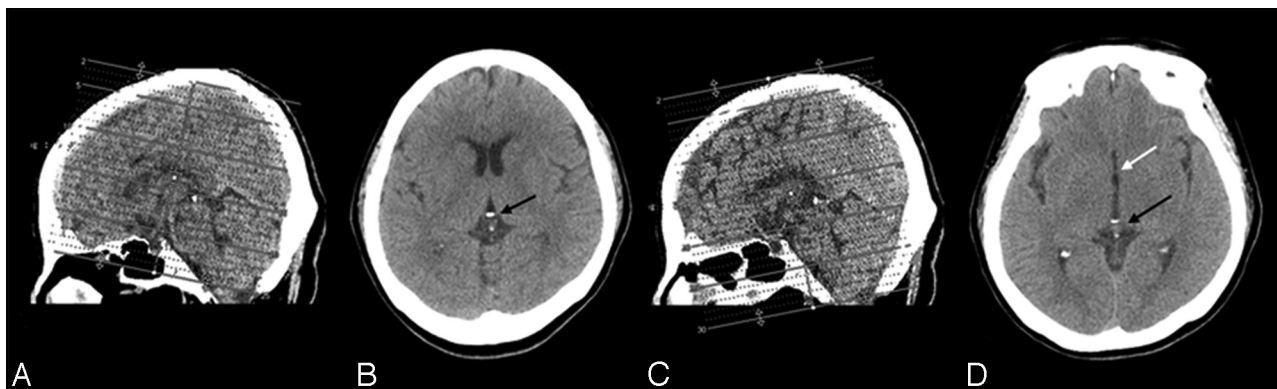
A, Scout topography of OML-based brain CT. B, Brain CT images based on the OML showing only the posterior commissure (black arrow) without inclusion of anterior commissure at the level similar to D. C, Scout topography of TS-OP line-based brain CT showing the scanning reference lines parallel to the line connecting the tuberculum sellae and external occipital protuberance. D, Brain CT image based on the TS-OP line showing both the anterior commissure (white arrow) and posterior commissure (black arrow) at the same level B.
